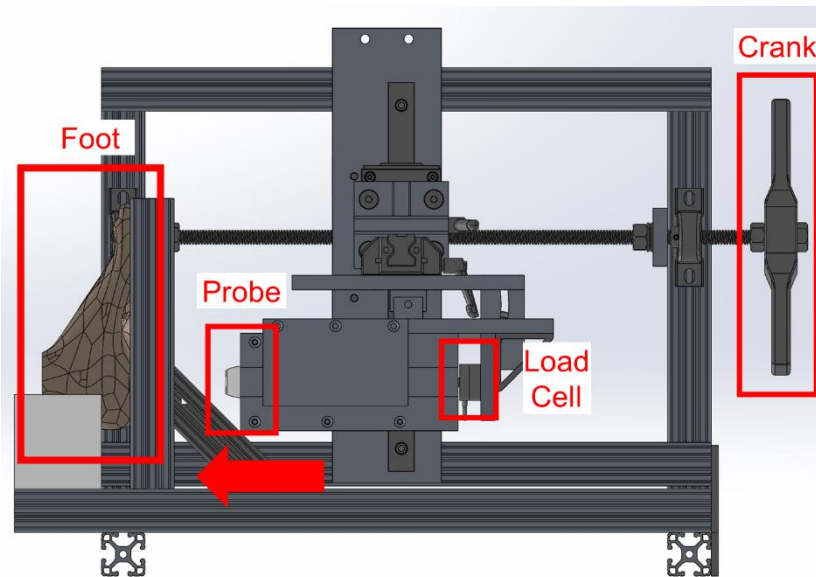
Simplified View of the Ultrasound Fixture
